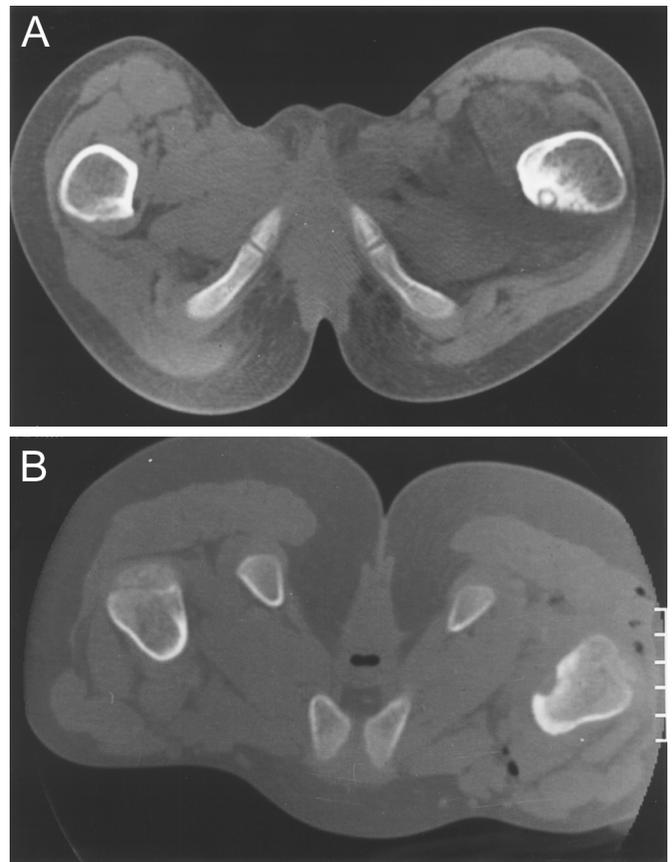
[A] Axial CT scan (while lying supine) showing osteoid osteoma in the cortex of the left femoral neck. [B] Postoperative CT scan (prone) showing complete removal of the nidus.
